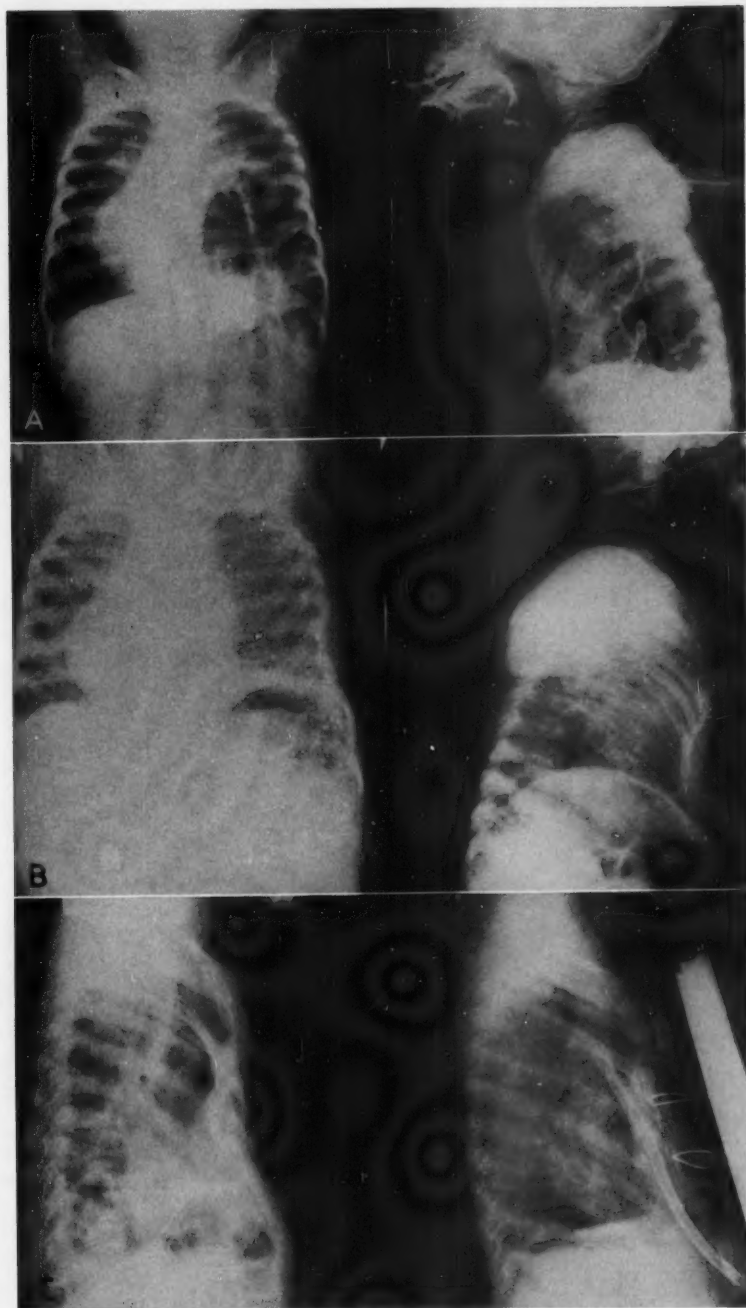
(A) Roentgenograms are of a thirteen pound, thirteen-month-old boy infant with a severe pectus excavatum and eventration of the left diaphragm. (B) The same patient seven months later after repair of the left diaphragmatic eventration followed in two months by an autogenous rib strut repair of the pectus excavatum. (C) The left lateral roentgenogram of the same patient eighteen months after the rib strut pectus repair shows a large osteofibrotic mass on the posterior surface of the sternum which markedly shortens the anteroposterior diameter of the chest. The lateral roentgenogram on the right shows the external traction apparatus after resection of the rib strut with marked increase in anteroposterior diameter of the patient's chest.
